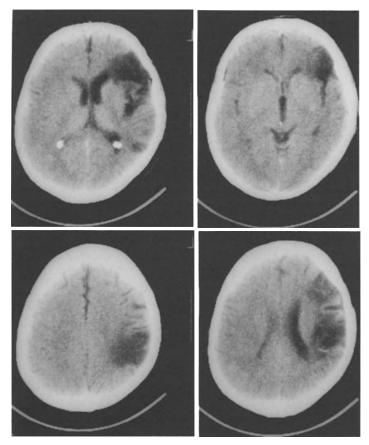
CT scan 11 years after embolic infarction in the left middle cerebral artery territory
